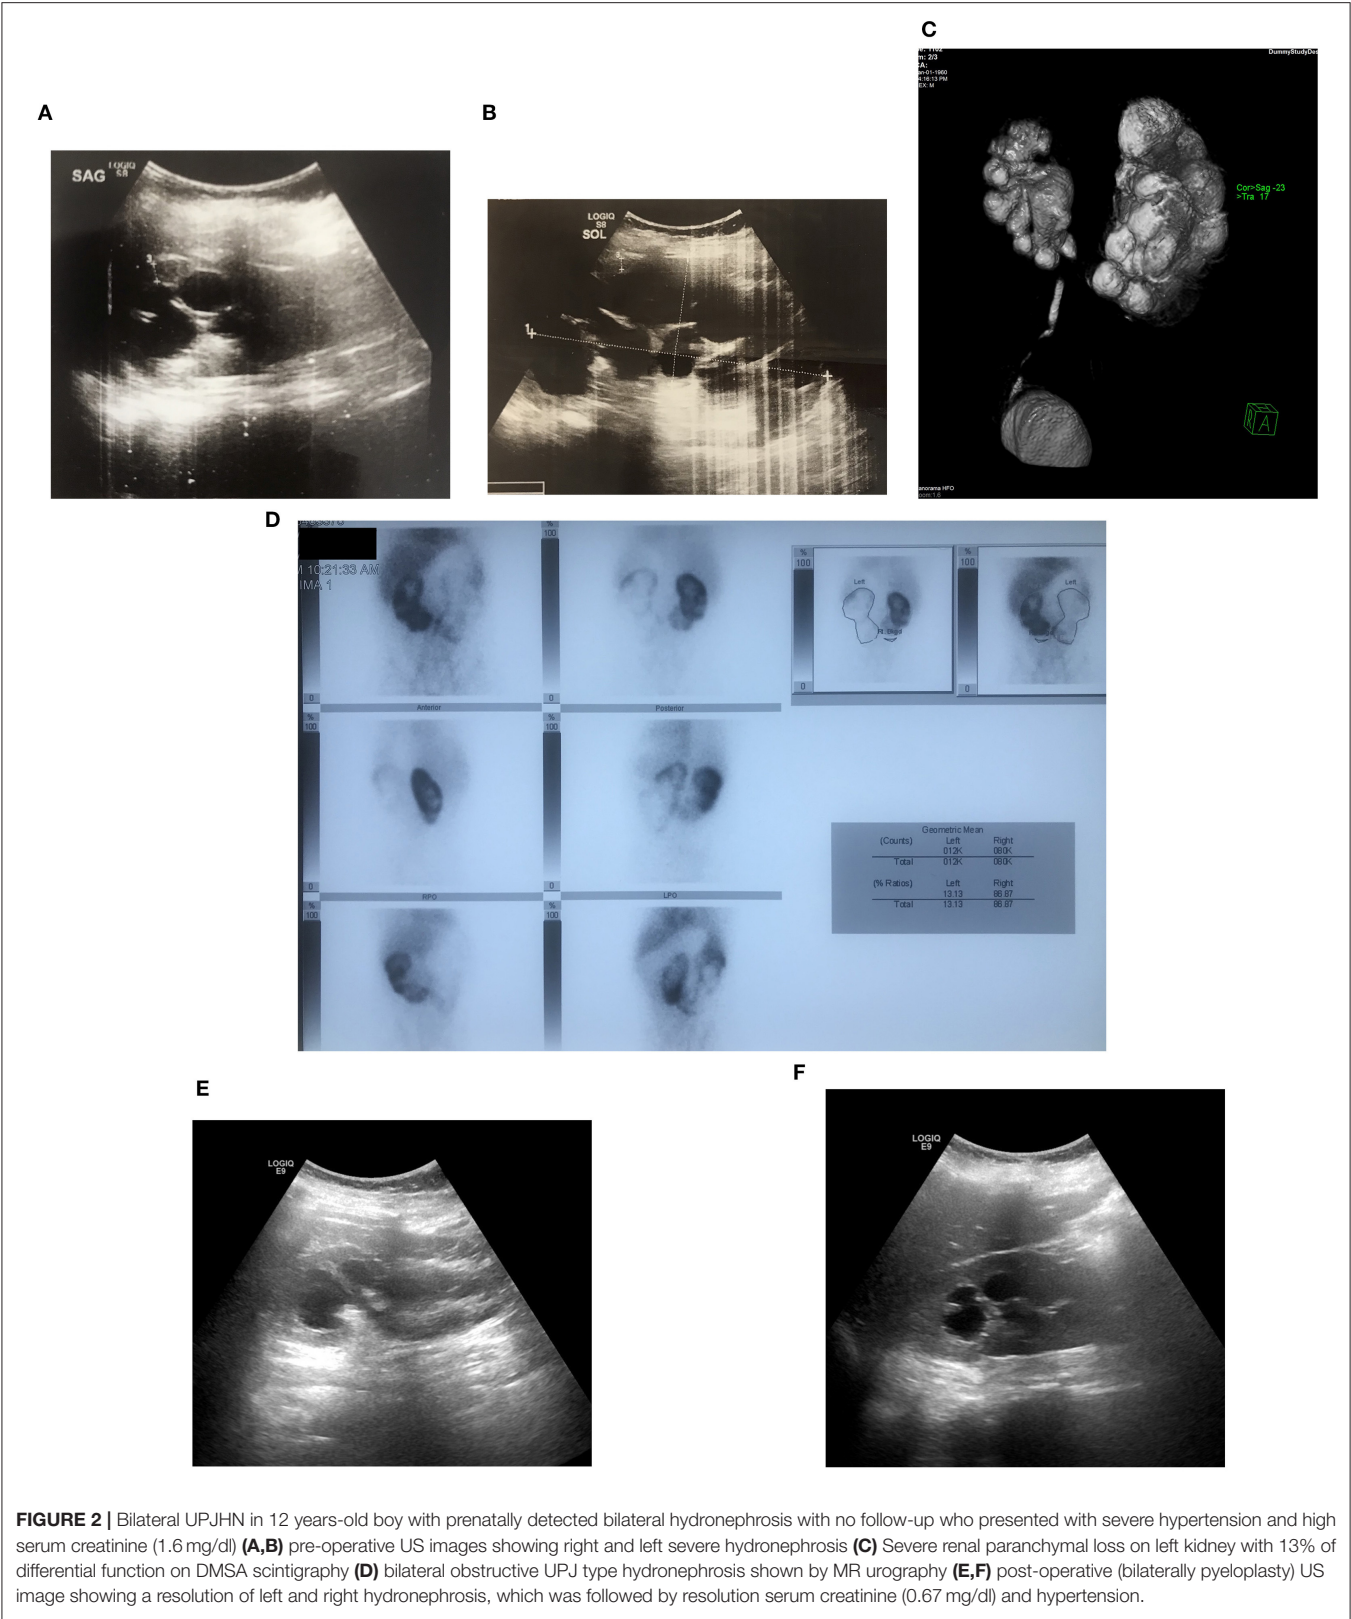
Bilateral UPJHN in 12 years-old boy with prenatally detected bilateral hydronephrosis with no follow-up who presented with severe hypertension and high serum creatinine (1.6 mg/dl) (A,B) pre-operative US images showing right and left severe hydronephrosis (C) Severe renal parenchymal loss on left kidney with 13% of differential function on DMSA scintigraphy (D) bilateral obstructive UPJ type hydronephrosis shown by MR urography (E,F) post-operative (bilaterally pyeloplasty) US image showing a resolution of left and right hydronephrosis, which was followed by resolution serum creatinine (0.67 mg/dl) and hypertension.
